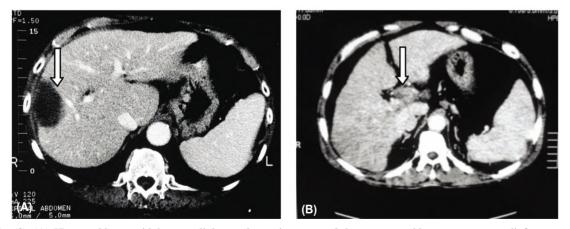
(A) 57-year-old man with hepatocellular carcinoma in segment 8 that was treated by percutaneous radiofrequency ablation (RFA) (arrow). (B) Transverse helical portal venous phase CT scan obtained 1 month after RFA. Nonenhancing filling defect (arrow) is present in main portal vein, (arrow).
